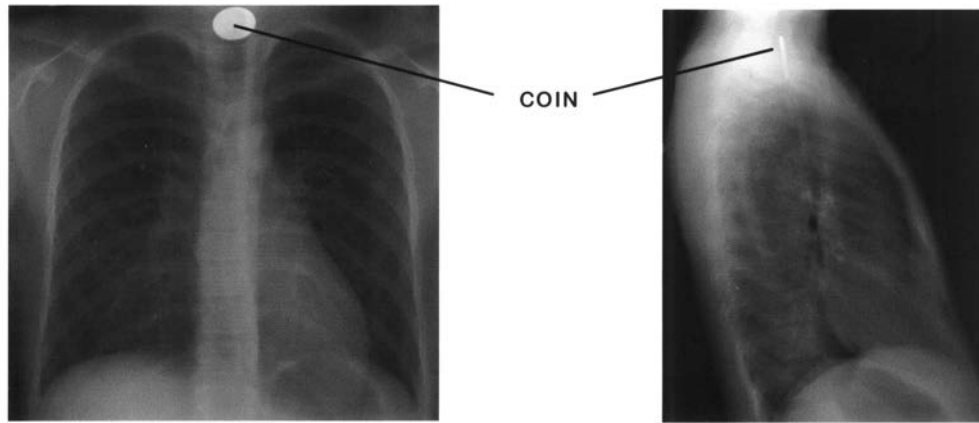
Esophageal foreign body. A coin in the esophagus will be seen flat or en face on an AP radiograph, and on its edge on a lateral view. (Used with permission from Dr. Julia Rosekrans.)
